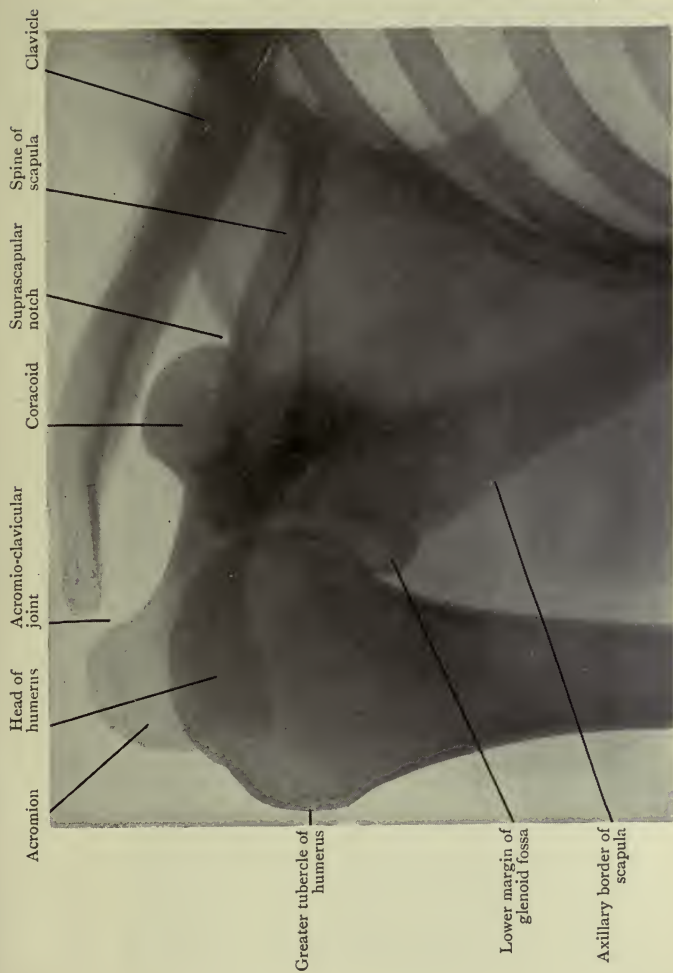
Radiograph of Shoulder Region with Arm by Side.
